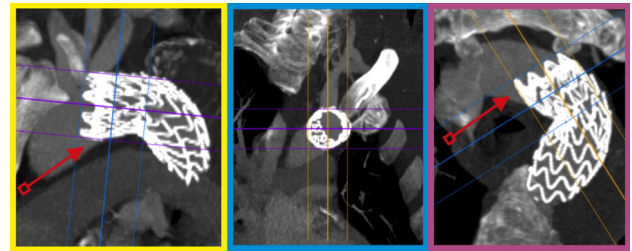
Multislice computed tomography with intravenous contrast agent administration. Thin-slab maximum intensity projection shows bird-beak configuration. At proximal end, the stent-graft has an imperfect apposition to the lesser inner curve of aortic arch, resulting in a wedge-shaped gap (see red arrow) between undersurface of the stent-graft and aortic wall
